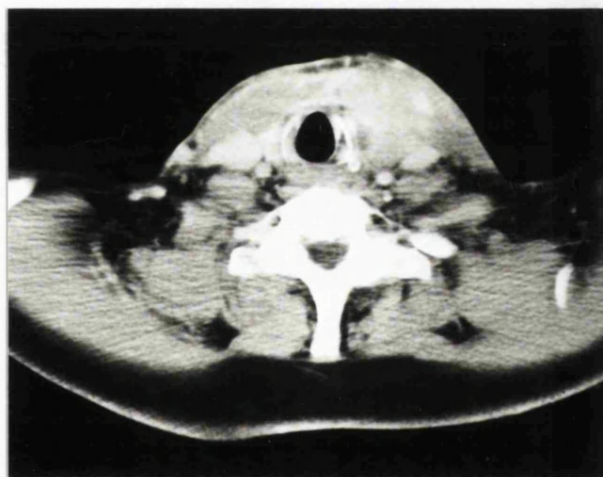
CT scan showing a mass on the left side of neck invading the sternomastoid muscle and inseparable from the vascular sheath with tracheal deviation to the right.
